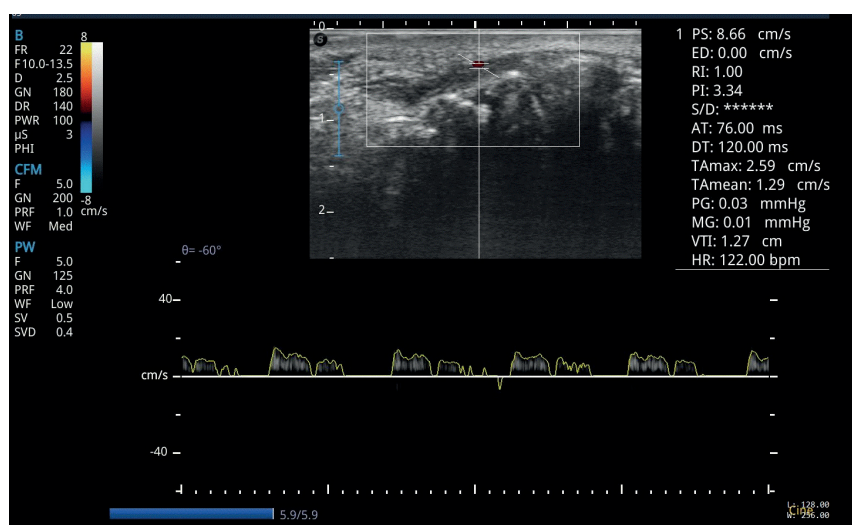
Periodontal tissues Doppler of patient S. of the comparison group, before treatment
